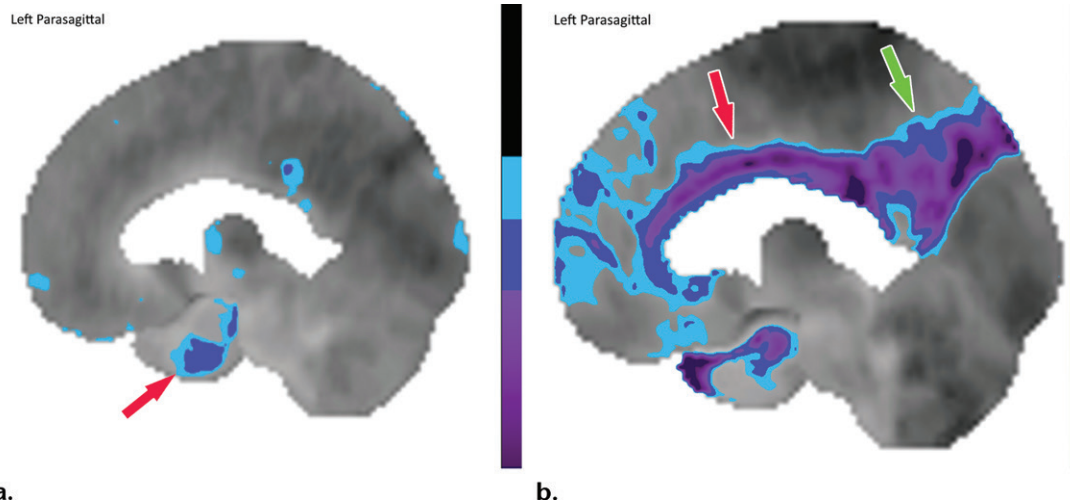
Computer-aided quantitation in FDG PET. (a) Sagittal color map of the z score of FDG uptake in a normal subject shows only minimal decreased uptake at the left mesial temporal lobe (arrow). (b) Sagittal color map in a patient with Alzheimer disease shows characteristic markedly decreased uptake along the cingulate gyrus (red arrow) and left precuneus region (green arrow). In these examples, light blue areas represent a z score between 1.6 and 2.3 (95–99th percentile), dark blue areas are between 2.3 and 3.1 (99–99.9th percentile), and purple areas are below 3.1 (99.9th percentile) standard deviations from those of normal examinations.
